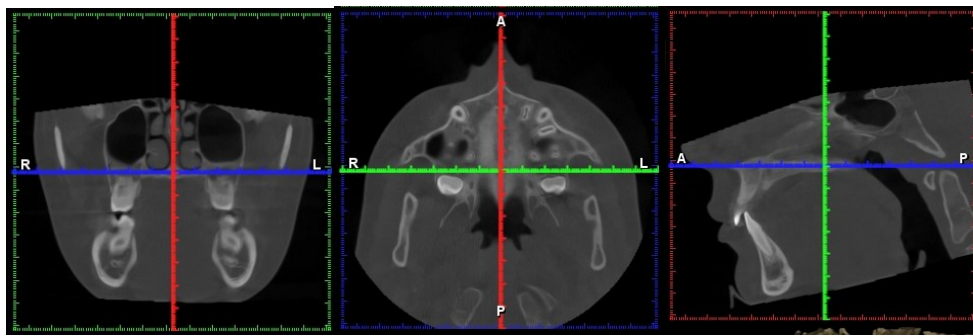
Standardisation of CBCT images in all three planes A - Coronal, B – Axial and C - Sagittal)
